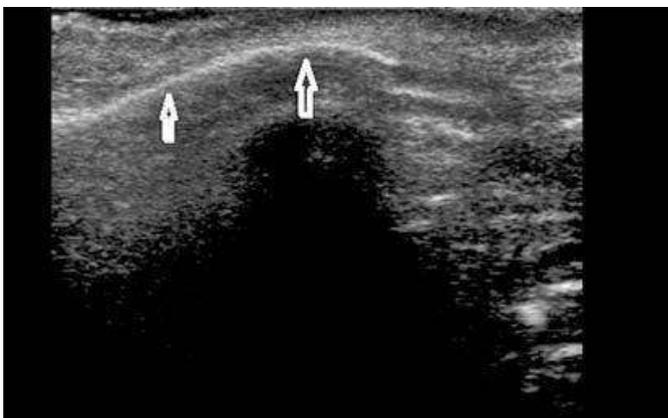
2. Oblique longitudinal ultrasonogram shows the normal appearance of the lateral wall of nasal bone as an echogenic line (arrows).
